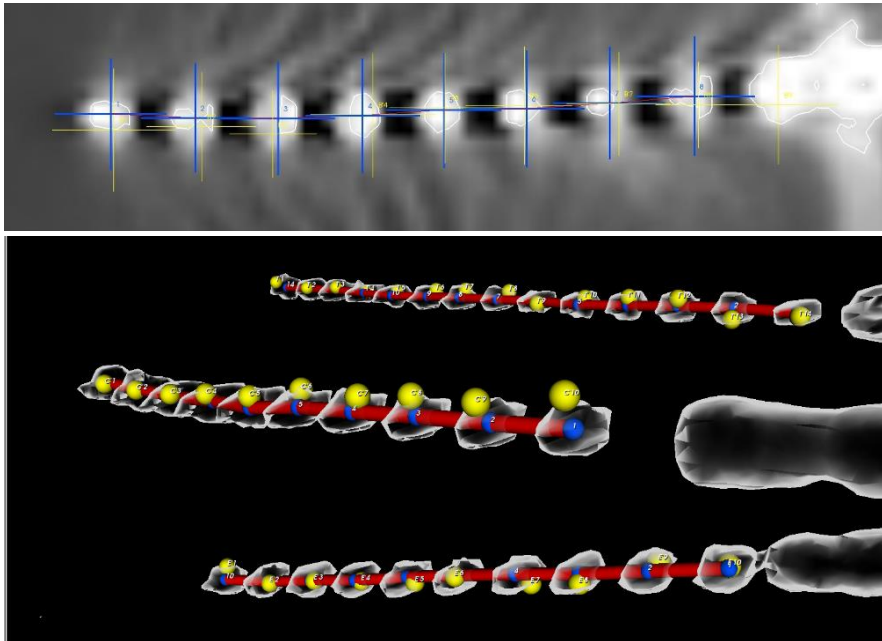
Automated contact segmentation. Comparison of the automatic (blue crosses and spheres) and manual (yellow crosses spheres) contact segmentation of SEEG electrodes from a postoperative CT scan.
